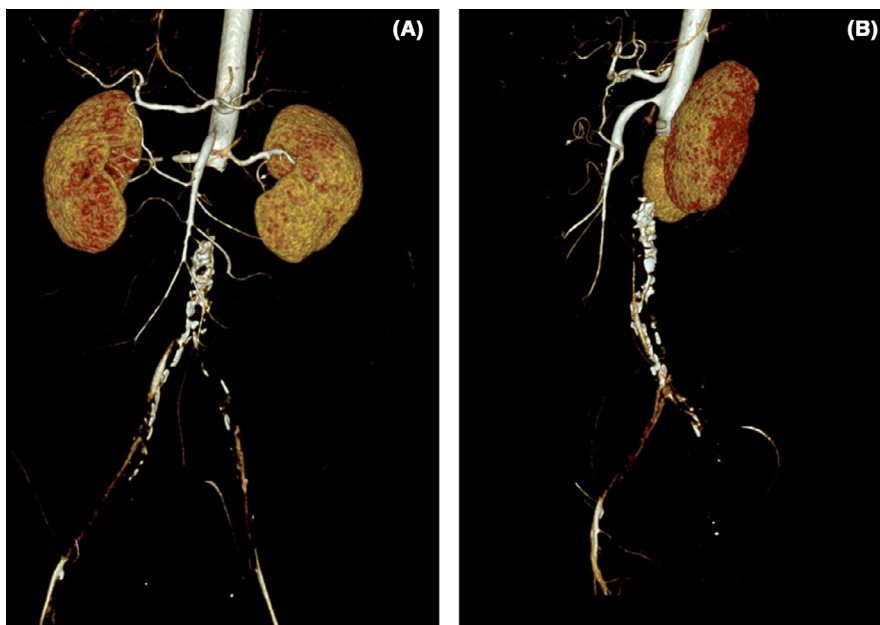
3D VRT (3-Dimensional Volume Rendering Technique) of Contrast Abdominal CT: Coronal (A) and Sagittal (B) view images showing complete occlusion of infra-renal abdominal aorta extending to the bifurcation level with narrowing of proximal SMA (superior mesenteric artery)
